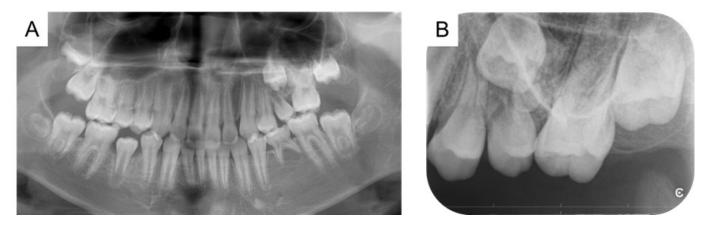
Radiographic examination at 9 years 9 months of age. (A) Panoramic radiograph. (B) Periapical radiograph around the maxillary left molars.
